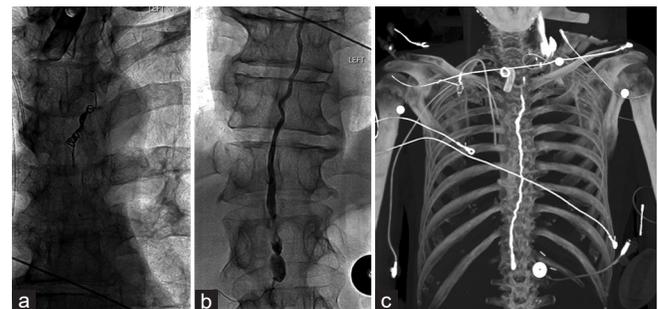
(a) Thoracic duct embolization performed using micro-nestor coils and onyx. (b) Postembolization lymphangiogram shows stasis of contrast within the lymphatic system with no extravasation. (c) angiography/computed tomography three-dimensional reconstruction verifies successful thoracic duct embolization without complications
